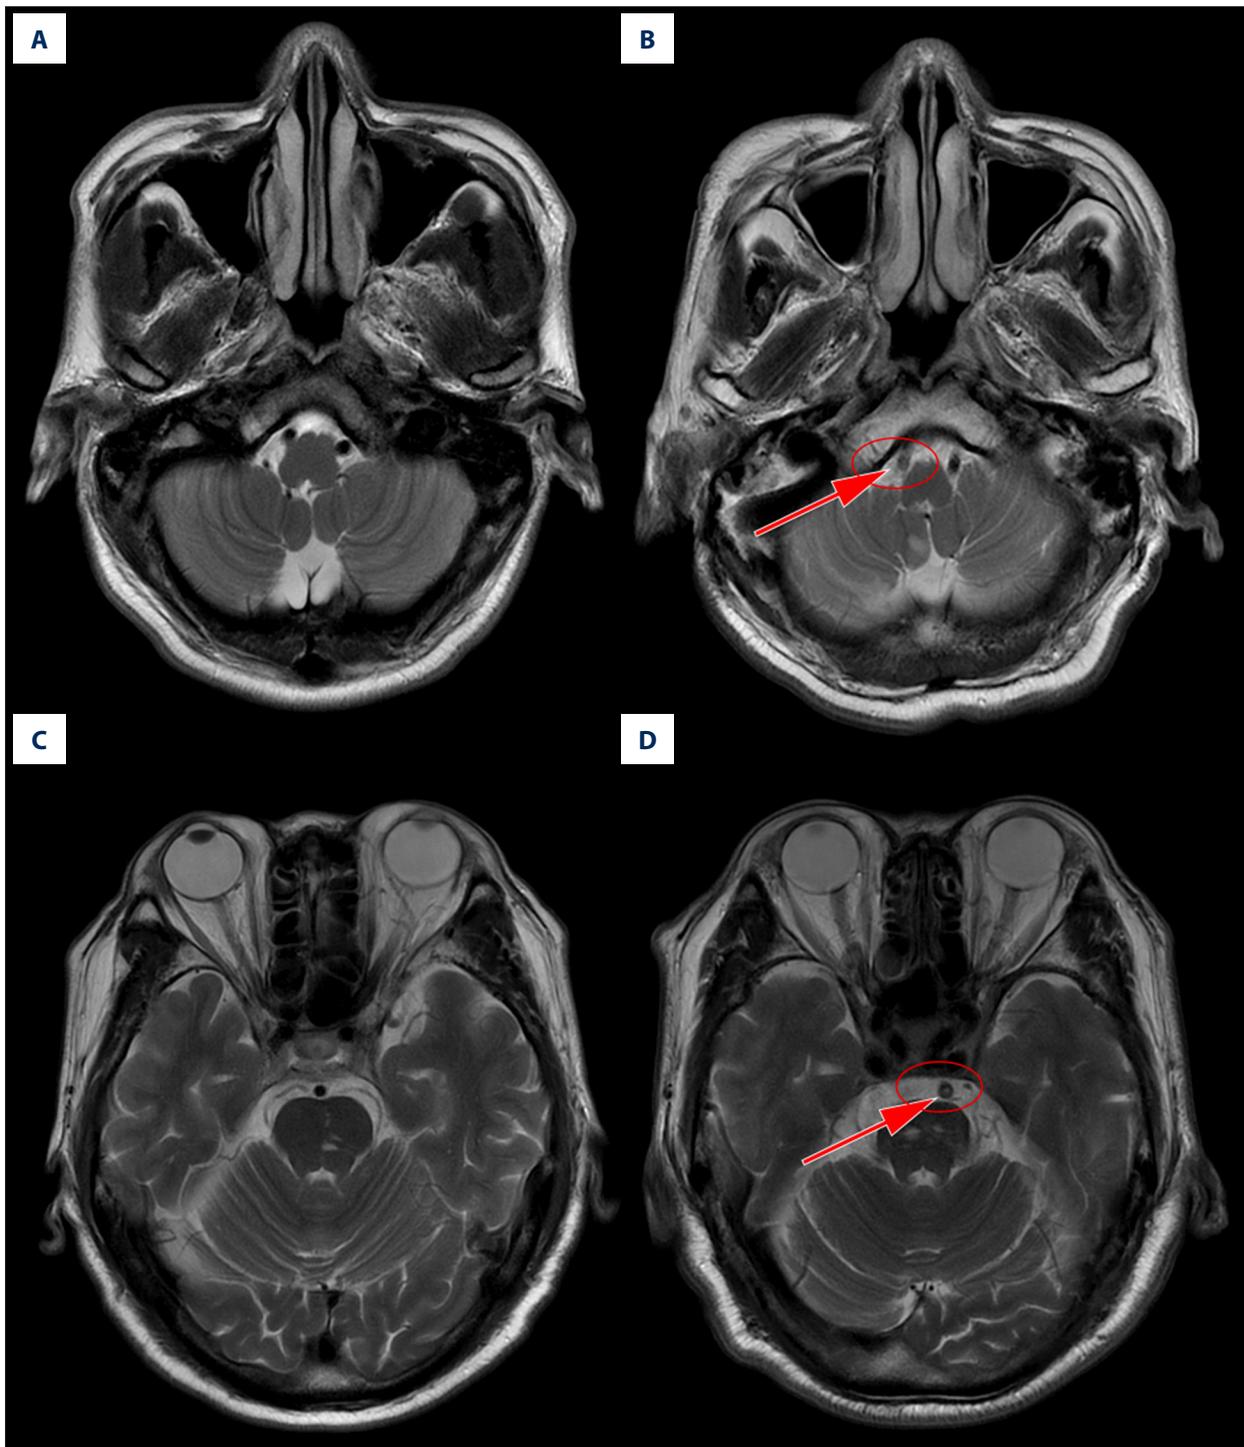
Vertebrobasilar artery HEVs imaging. (A, C) Vertebral artery and basilar artery had normal lumen, and flow void phenomenon existed on MRI T2. (B, D) Flow void phenomenon of vertebral artery and basilar artery disappeared and was partly filled by HEVs on MRI T2, suggesting that the endo-vertebrobasilar artery thrombosis had recently developed (arrow).
